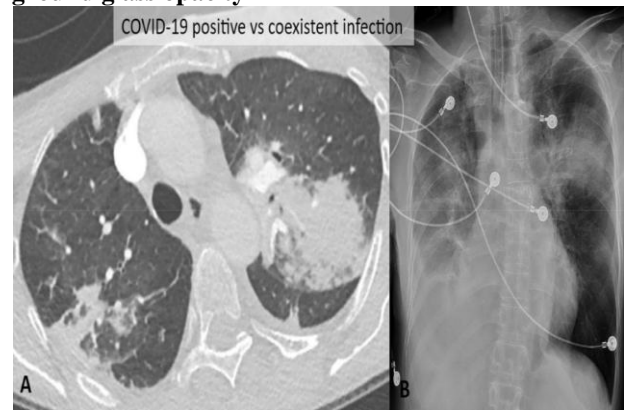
Contrast-Enhanced Axial Computed Tomography Image (A) And Frontal Chest Radiograph (B) Showing Segmental Consolidation Without Significant GGO.
